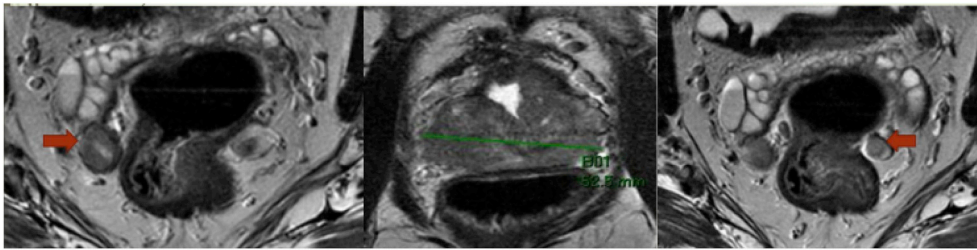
Prostate MRI images. Left – enlarged 1.3 cm right pelvic lymph node (red arrow), middle – 5.3 cm prostate lesion, right – enlarged 0.9 cm left pelvic lymph node (red arrow). (For interpretation of the references to colour in this figure legend, the reader is referred to the Web version of this article).
